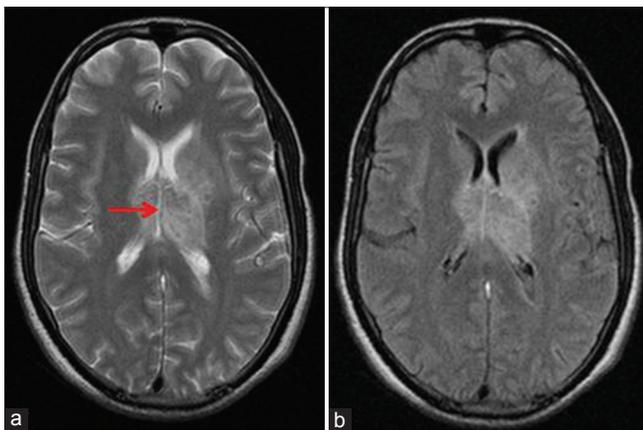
T2WI and FLAIR MRI sequences showing abnormal hyperintensity in the thalamus bilaterally, extending into left basal ganglia and periventricular white matter (a, b respectively), hyperintense signal on T2WI in the internal cerebral veins diagnostic of thrombosis of the deep venous system (red arrow) (a)
